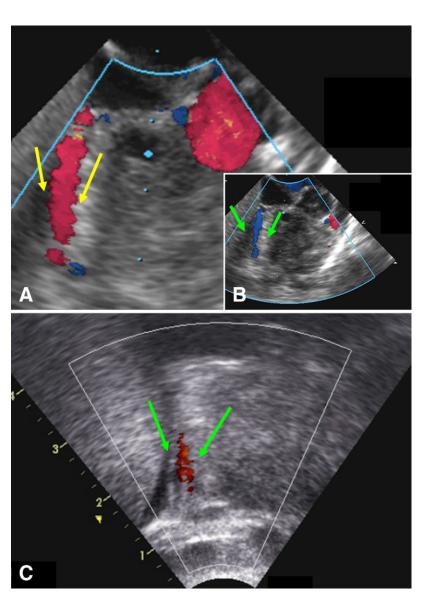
Coronary artery flow signals are used initially to establish continuity with the aorta and, later, to assess the effects of RV-CAC ligation. In this case, flow between the aortic root and the right coronary artery (RCA) is shown before and after ligation of a more distal RV-CAC. (A) Transesophageal echocardiography revealed retrograde flow from the RCA into the aortic root, which demonstrated both aortic-coronary continuity and the presence of higher pressure in the connection with retrograde flow into the aorta (Video 4 and Video 5). (B) After ligation, only antegrade flow into the RCA from the aortic root was seen, indicating elimination of the connection (Video 6). Ao = aorta; MPA = main pulmonary artery; RCA = right coronary artery.
